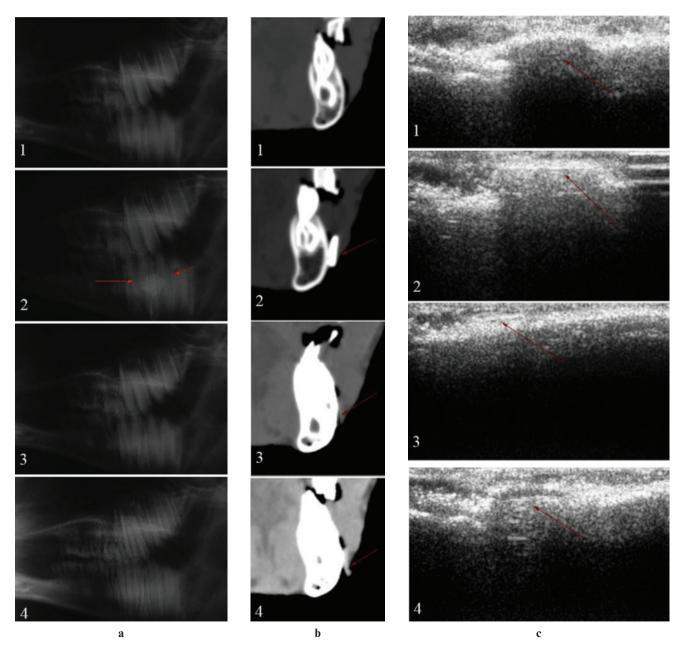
Visibility of foreign body on bone. (a) Conventional plain radiography. (b) CT. (c) Ultrasonography. 1, dry wood; 2, stone; 3, acrylic; 4, Bakelite
